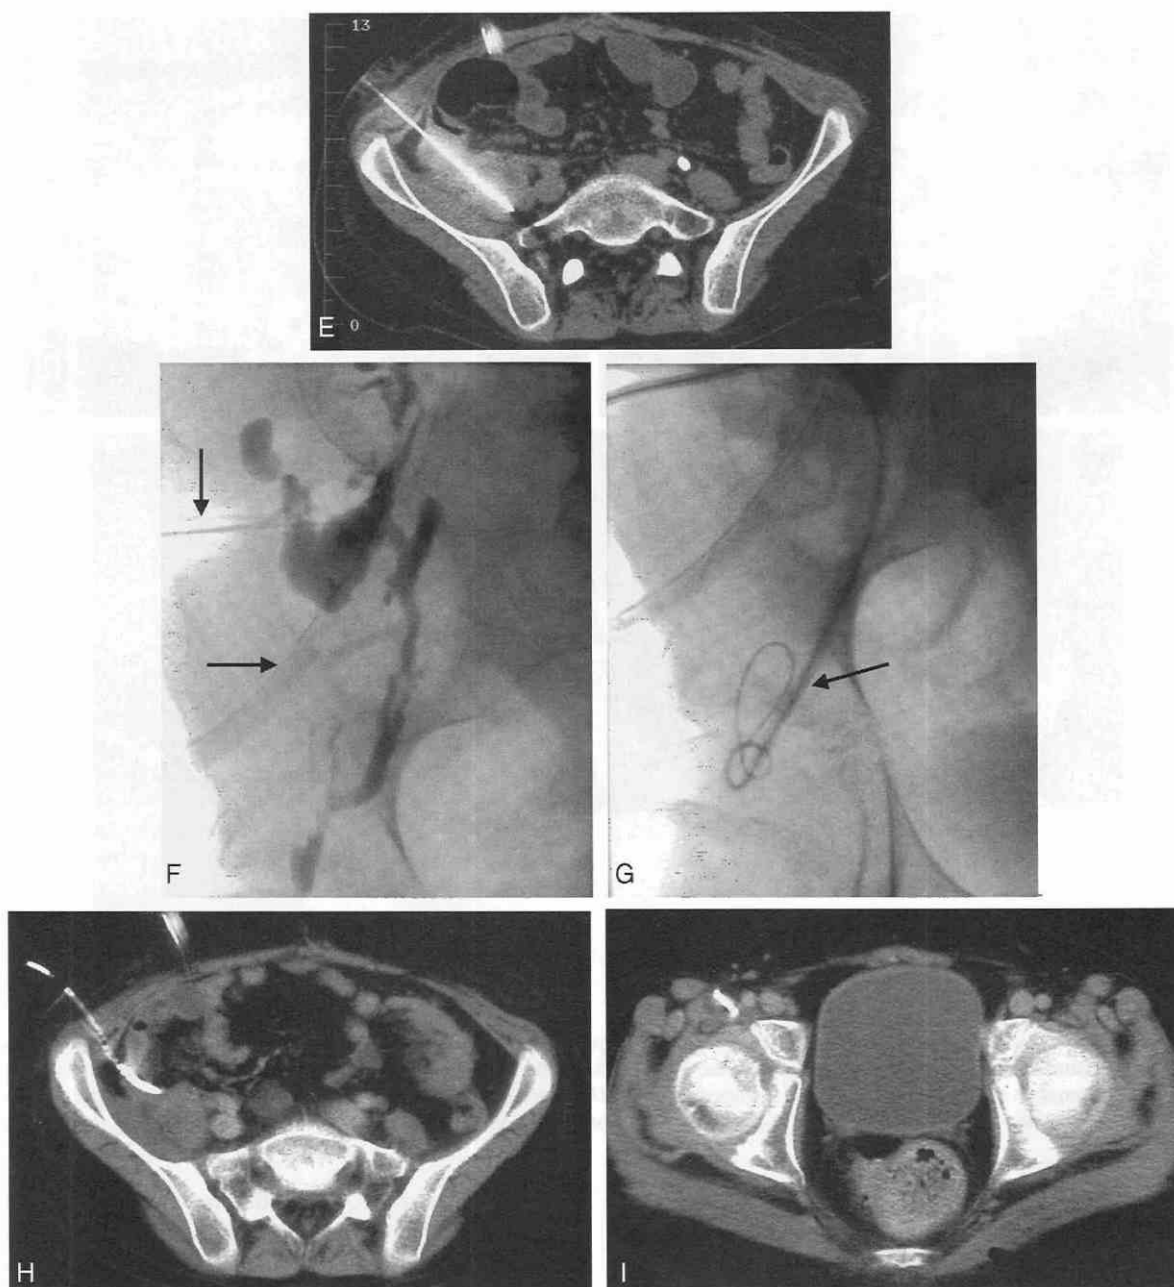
E to I*, The five images show the proper procedure with positioning of the catheter. In *E*, the needle puncture through the widest extent of the abscess was made. In *F*, the CT catheter (*vertical arrow*) is seen as it is used to perform a sonogram of the cavity that flows down through the psoas over the femoral head. The *horizontal arrow* shows the surgical catheter previously placed, which did not drain the abscess. In *G*, the wire and catheter were manipulated to follow the entire length of the cavity. In *H* and *I*, the axial scans show the upper and lower extent of the catheter in all portions of the abscess.
